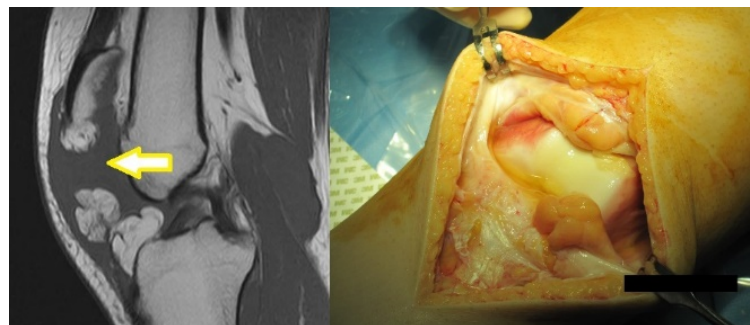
Magnetic resonance imaging (MRI) of the right knee: complete resorption of the patellar tendon by the surrounding tissue and separation of the infrapatellar pads (yellow arrow).
